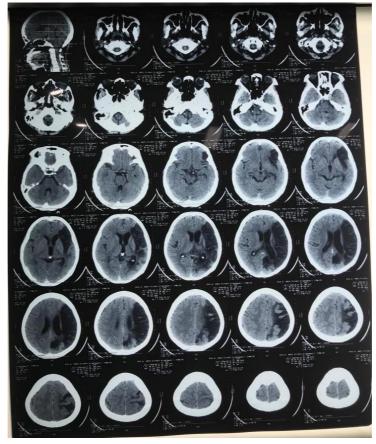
Non-contrast Head CT
